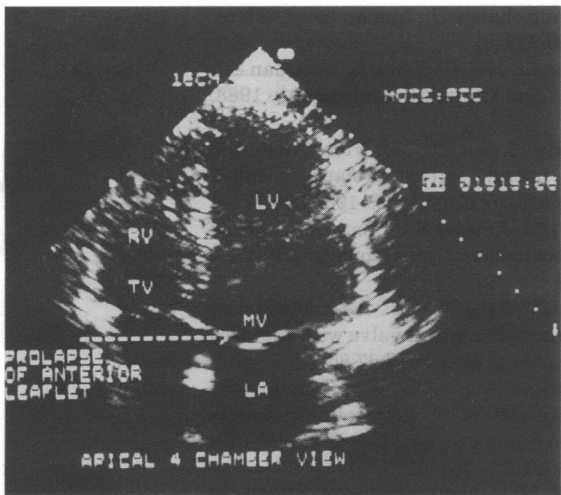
Two-dimensional echocardiogram of the same patient in Figure 1 showing prolapse of the anterior leaflet of the mitral valve (MV - LA, left atrium; LV, left ventricle; RV, right ventricle)
